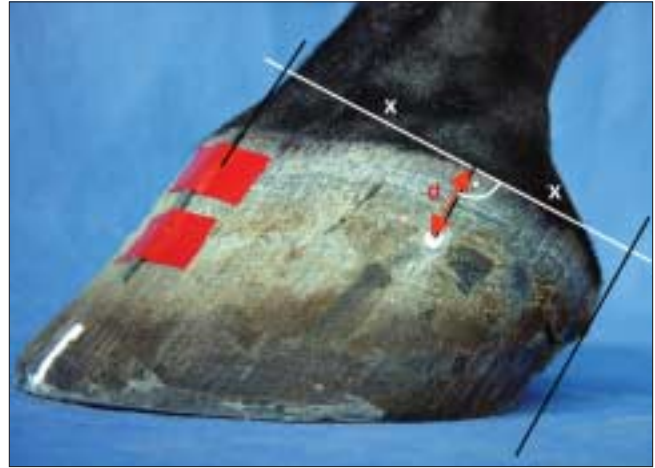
Main beam of the X-Ray generator is positioned 2 cm (d) below the coronary band and at a right angle to the middle of the line between the bulbs of the heel and the dorsal aspect of the hoof wall.
